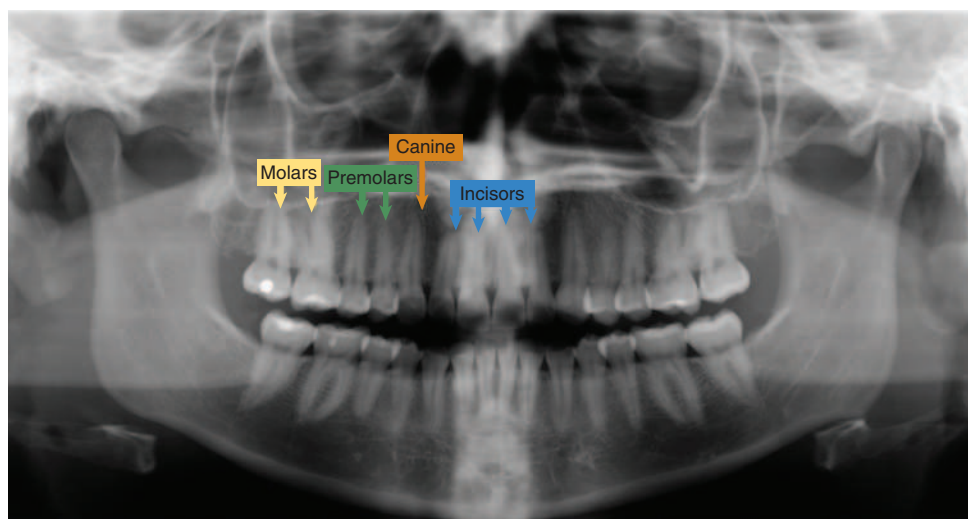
Panoramic radiograph of adult dentition.
